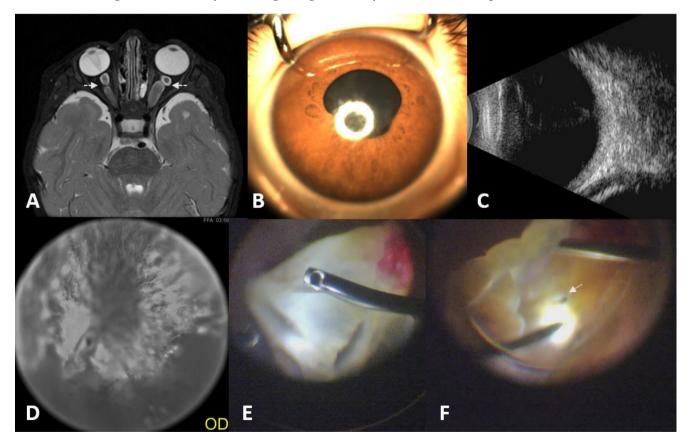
Cranial MRI showing bilateral optic glioma (arrows) (A). Pupillary dilation was poor due to posterior synechiae in the right eye and leukocoria was noted (B). B-scan ultrasonography demonstrated closed funnel-shaped retinal detachment (C). Fluorescein angiography showed diffuse leakage and capillary loss, which was more apparent in the inferior periphery of the right eye (D). Following lensectomy and removal of the retrolental fibrotic membranes, a macular tear was seen within the funnel (arrow) (E, F). Fundus images and fluorescein angiography images were taken with the SW8000 widefield fundus camera by Suoer (Tianjin, China) *MRI: Magnetic resonance imaging*
